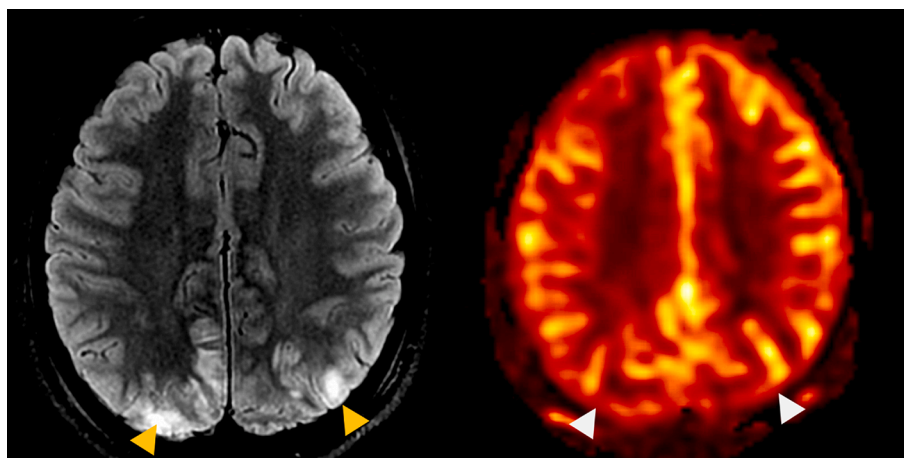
Axial T2 FLAIR (left) and ASL color (right) perfusion maps in an 18-year-old female with eclampsia induced PRES. No convincing altered perfusion was seen on ASL corresponding to the regions of FLAIR hyperintensity (yellow arrowheads) or elsewhere. (For interpretation of the references to color in this figure legend, the reader is referred to the web version of this article.)
